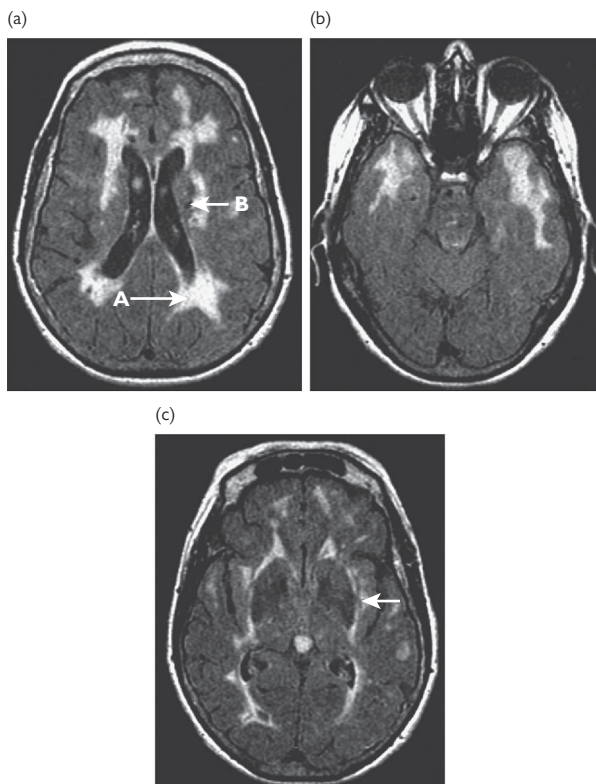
FLAIR MRI appearances of CADASIL: (a) showing both leucoaraiosis (arrowed A) and focal lacunar infarction (arrowed B); (b) typical involvement of the anterior temporal pole can be seen in a CADASIL patient; (c) this scan shows involvement of the external capsule (arrowed). © Hugh Markus.
